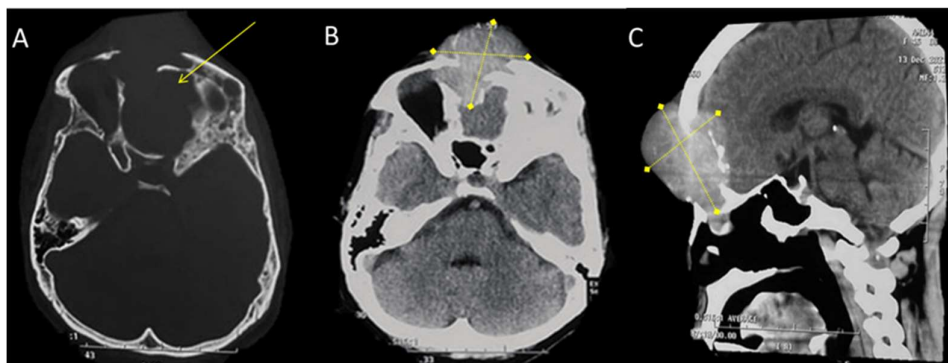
Head computed tomography (CT), A. Bone window axial view showed sinonasal bone destruction, B. Brain window axial view invasion of the tumor to the sinonasal, C. Brain window sagittal view showed large tumor come from intracranial.
